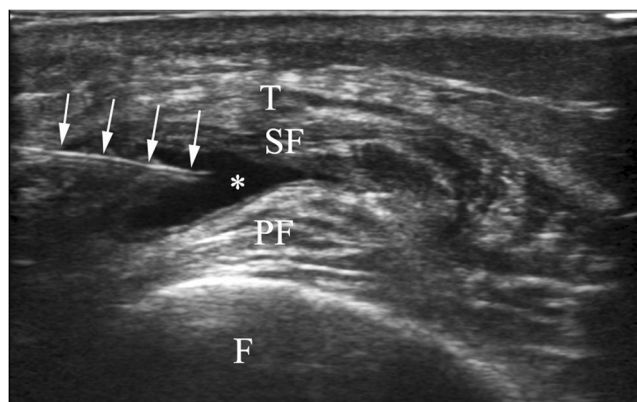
Ultrasound-guided suprapatellar pouch injection in transverse (short axis) view (F, femur; T, quadriceps tendons; SF, suprapatellar fat-pad; PF, prefemoral fat-pad; asterisks, suprapatellar pouch; white arrows, needle)
